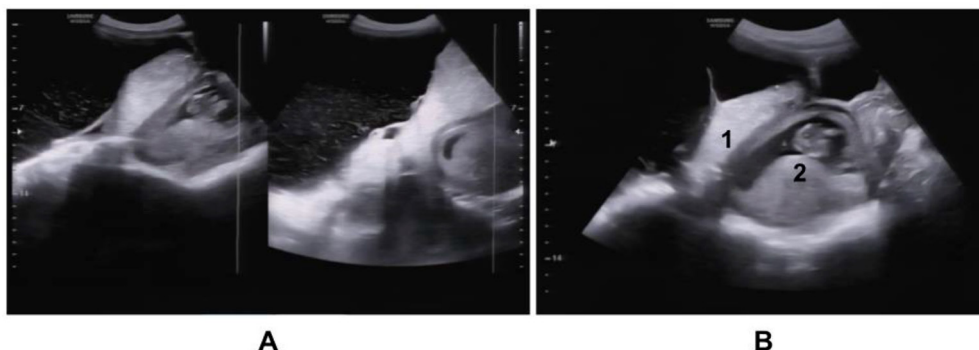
Ultrasound images of the solid-cystic adnexal structure (A and 1B) and the gravid uterus (2B).
